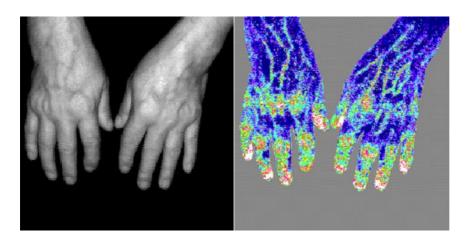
Laser Doppler perfusion images of arthritic hands, Obtained from [146]
